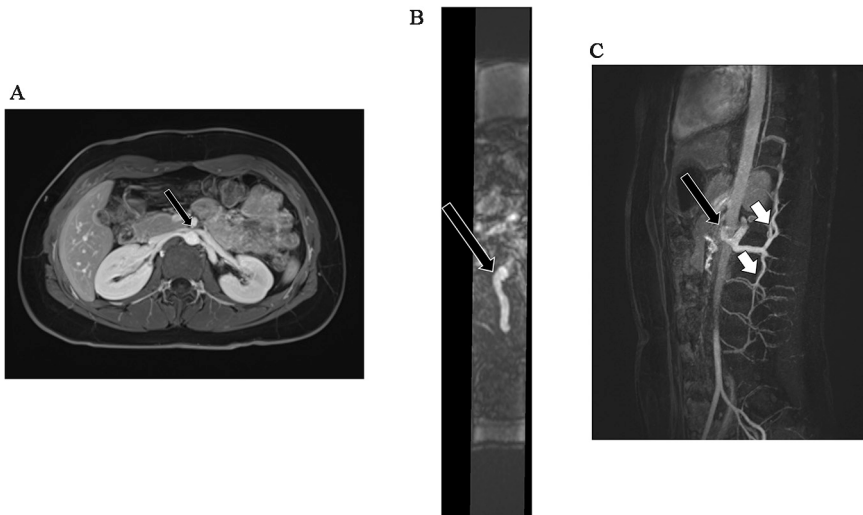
18-year-old woman with a 3-year history of a daily persistent headache from onset, worse in the Trendelenburg position, no response to CSF volume lowering medications, but improved with CSF volume removal with lumbar puncture. A. Contrast-enhanced MRI Axial image demonstrates left renal vein compression between the aorta and superior mesenteric artery (black arrow). B. Reformatted axial image from time-resolved contrast-enhanced sagittal MR angiogram showing retrograde flow through a dilated lumbar vein (black arrow). C. Time-resolved contrast enhanced sagittal MR angiogram noting retrograde flow through the left renal vein (black arrow), dilated lumbar vein and early opacification of the spinal epidural venous plexus (white arrowheads).
